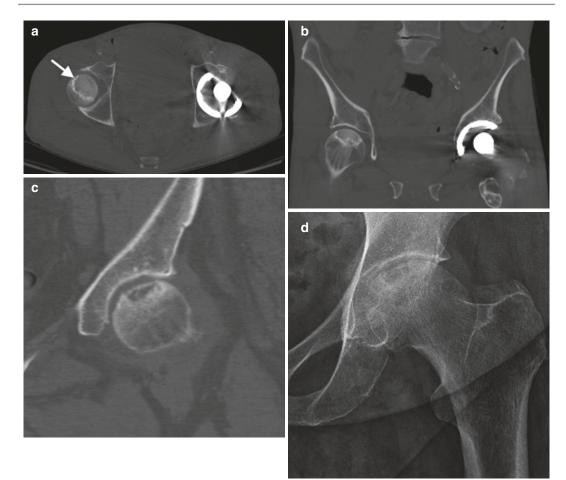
CT AVN in a 63-year-old male COPD patient with a history of steroid use, prior left THR secondary to advanced AVN. (a) Axial and (b) Cor reformatted CT of bilateral hips demonstrate increased sclerosis of the right
